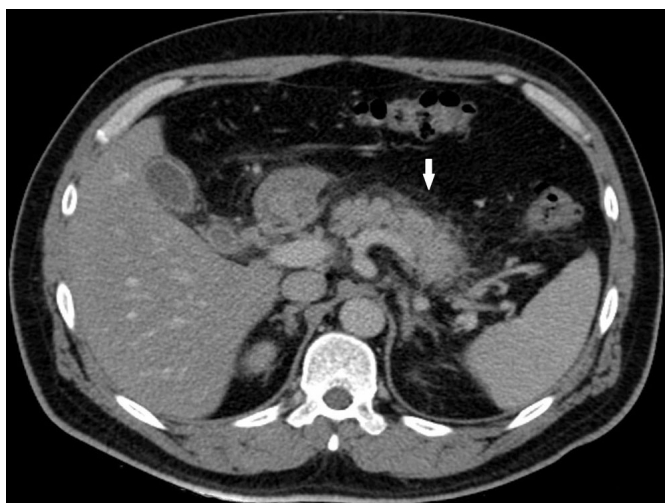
A 46-year-old male patient, Pancreatitis on abdominal CT, inflammation lines due to inflammation in the fat tissue planes surrounding the pancreas (white arrow)
